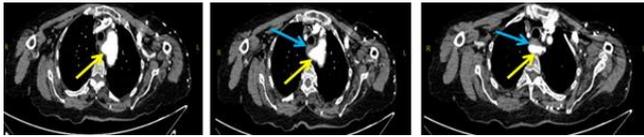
Aberrant right subclavian artery (yellow arrow) detected in contrast-enhanced thorax CT and the esophagus constricted by the pressure of the artery (blue arrow)
